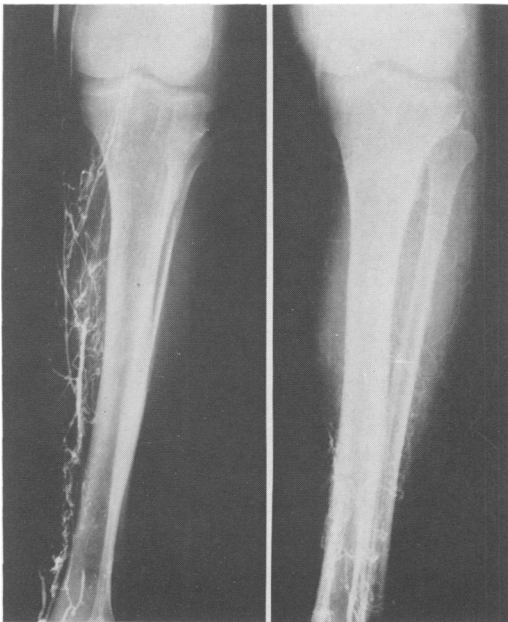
A. (Left). Case 13. X-ray picture of venogram showing complete obstruction of deep venous system in the calf and popliteal fossa. B. (Right). Further venogram showing obstruction of deep veins beginning at the lower one quarter of the left calf.
